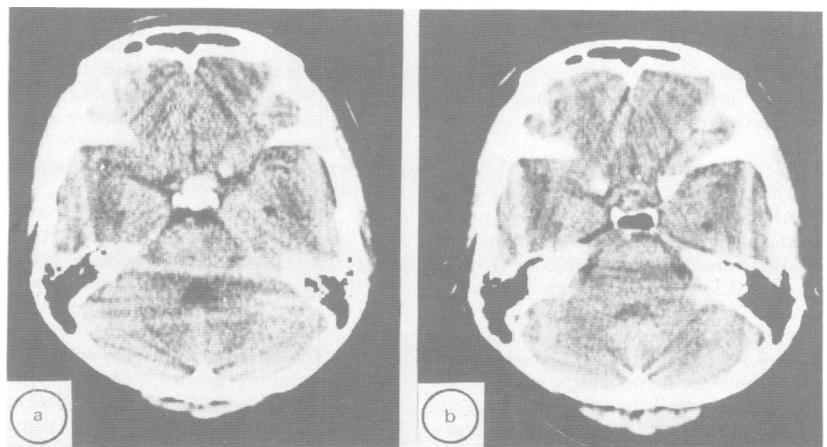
Fig CT without contrast medium, showing a juxtaseilar high density mass (A) 1 day and (B) 42 days after the onset of symptom.
